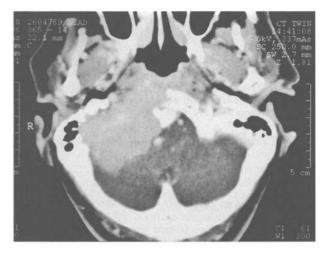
Axial contrast CT scan of the posterior cranial fossa.
